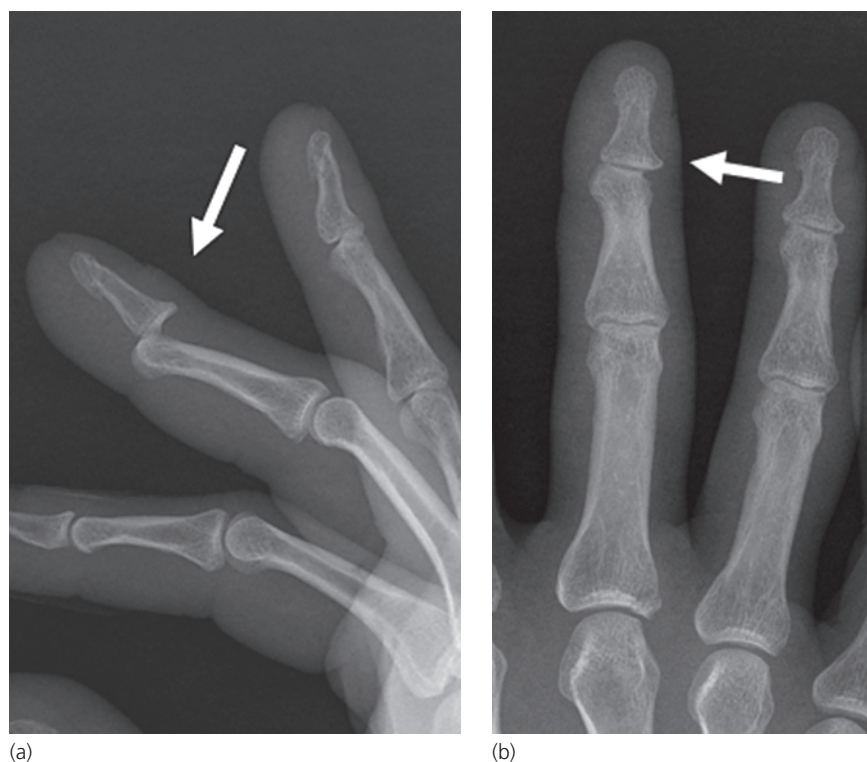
Dislocation at the distal interphalangeal joint. (a) Lateral and (b) PA radiographs show a dorsal dislocation and the DIP joint to the long finger (arrows).
